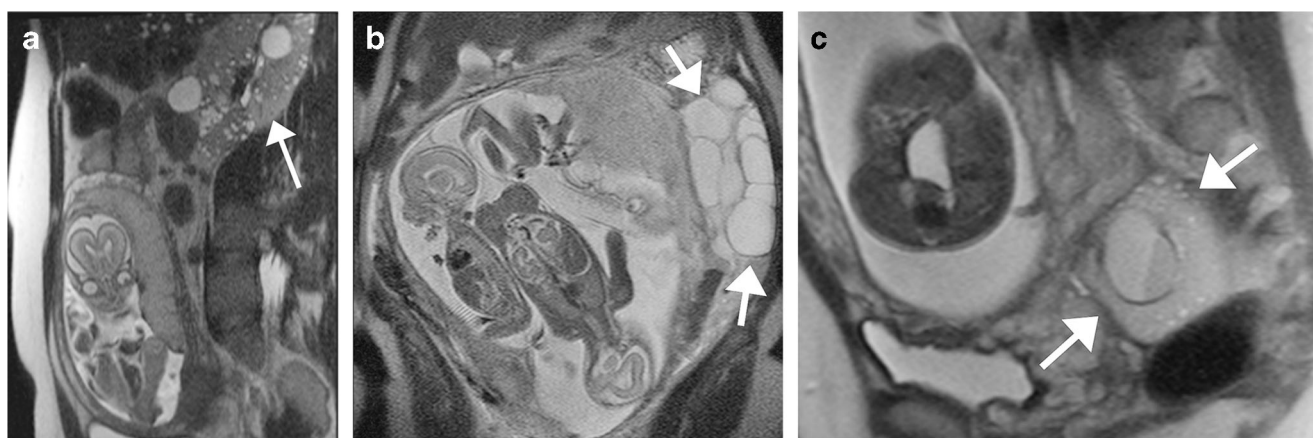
Abnormal maternal findings found at fetal MRI. Attention must always be paid to the maternal organs in a fetal MR examination. a Imaging in a 19-week fetus with neck mass (not shown). The maternal kidney shown in this single-shot turbo spin-echo (SSTSE) sagittal image demonstrates numerous parenchymal cysts (arrows) in this 31-year-old woman with an, until then, unknown diagnosis of polycystic kidney
